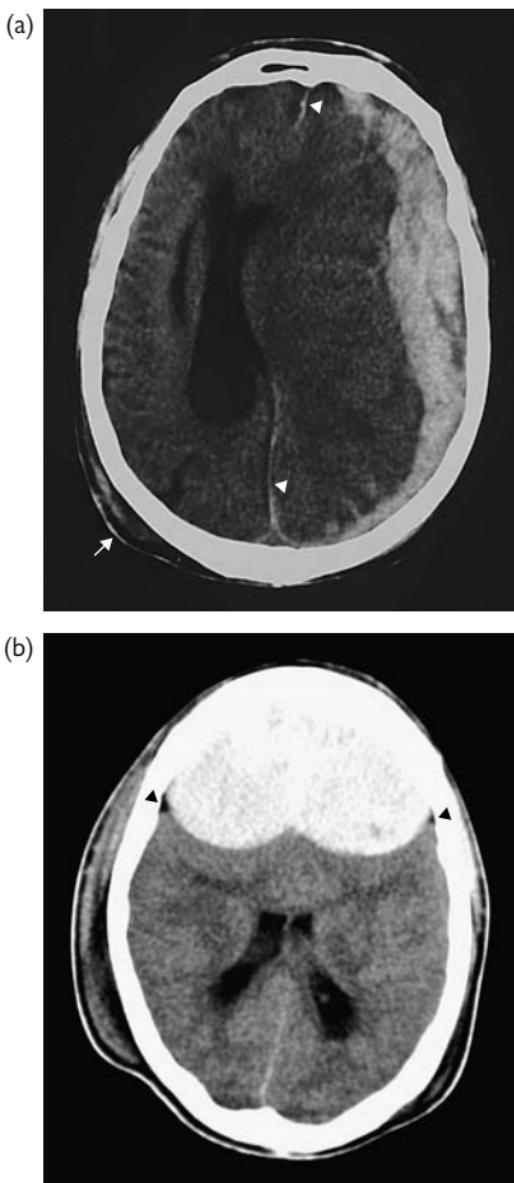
Acute extraaxial haematoma. (a) and (b): non-enhanced CT. A large acute subdural haematoma with crescentic configuration overlying the left cerebral convexity with minor extension into the interhemispheric fissure (white arrowheads). There is marked associated mass effect with ipsilateral sulcal and ventricular effacement and severe midline shift. Note the indirect site of impact over the right parietal bone (white arrow). By contrast note the CSF clefts (black arrowheads) associated with a bifrontal extradural haematoma in (b) which has a biconvex configuration. The frontal horns of the lateral ventricles are grossly effaced.
